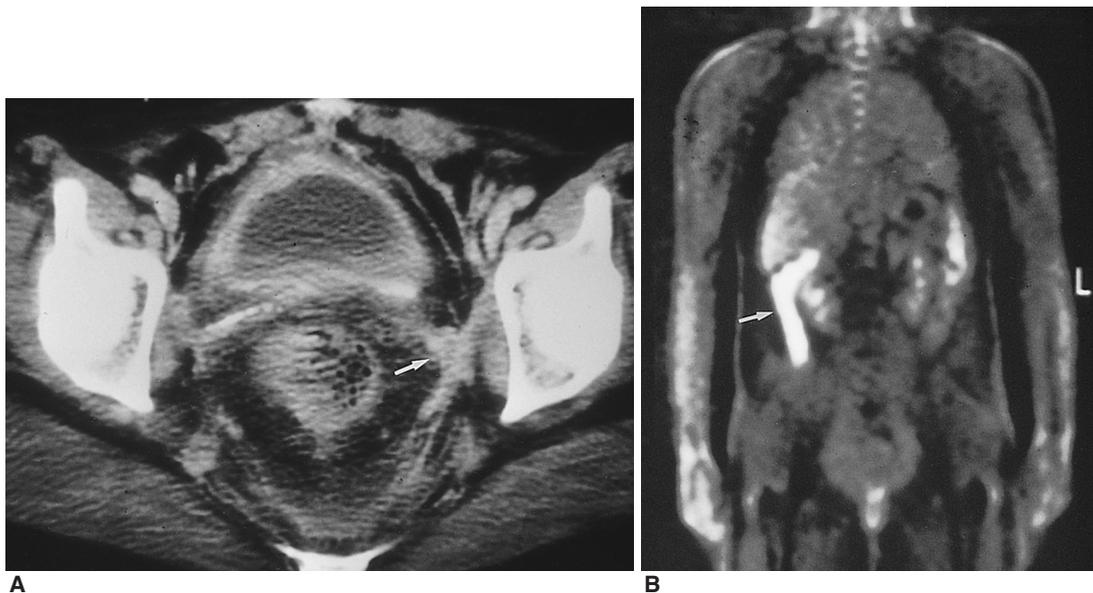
A 39-year-old woman who had undergone radical hysterectomy due to uterine cervical carcinoma. A. Enhanced CT scan shows soft tissue mass on the left pelvic side wall (arrow). B. PET scan shows no hypermetabolic site in the pelvis. Since no interval change was seen during follow-up study, we concluded that this was a case of postoperative fibrosis. The highly metabolic lesion in left abdomen (arrow) is due to artifactual accumulation of FDG in ascending colon.
